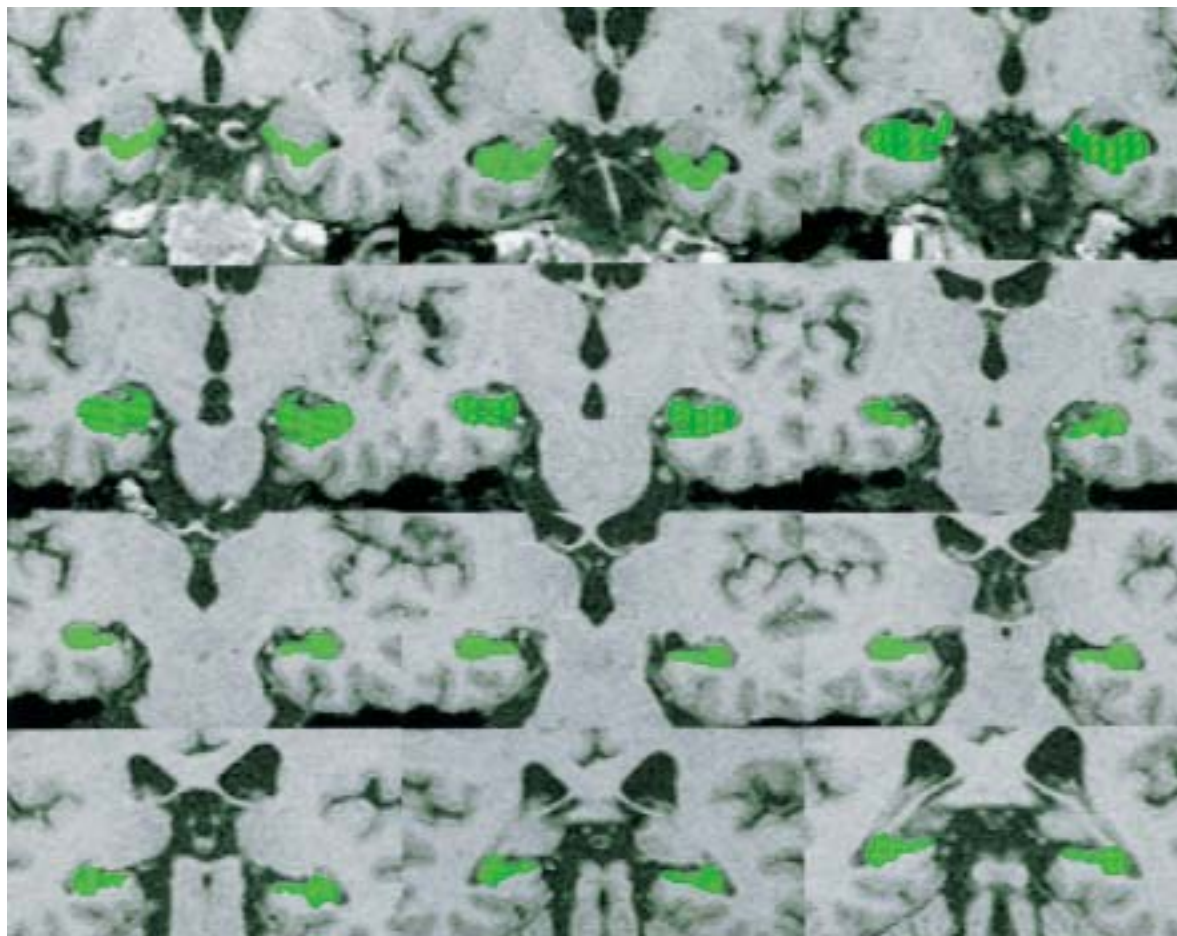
A selection of coronal T1-weighted images from a 3D dataset is shown. The hippocampal formation (including Ammon's horn (CA), subiculum, dentate gyrus and part of the alveus) are indicated by green regions of interest
